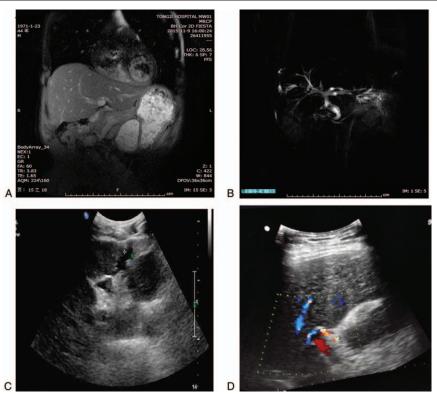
Imaging examination. (A, B) Preoperative magnetic resonance imaging showed no sign of portal vein thrombosis. Calculi were present in the main and left hepatic bile ducts. (C) Preoperative ultrasonography showed no signs of portal vein thrombosis. (D) Ultrasonography showed thrombosis in the main portal vein and left portal vein. The direction of flow in the portal vein was countercurrent (shown by blue color in Doppler ultrasonography).
